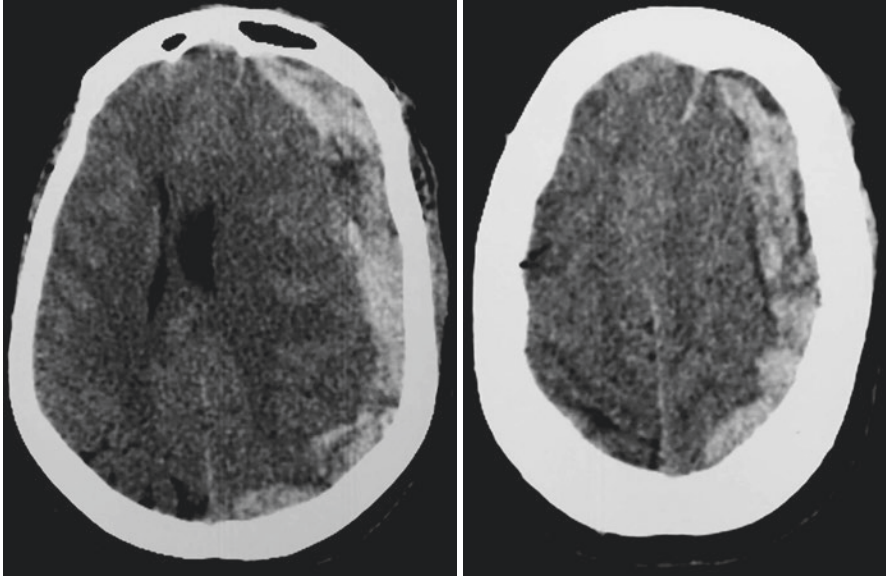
Head axial CT scan: spontaneous (non-traumatic) left acute subdural hematoma in a patient receiving anticoagulant agent
